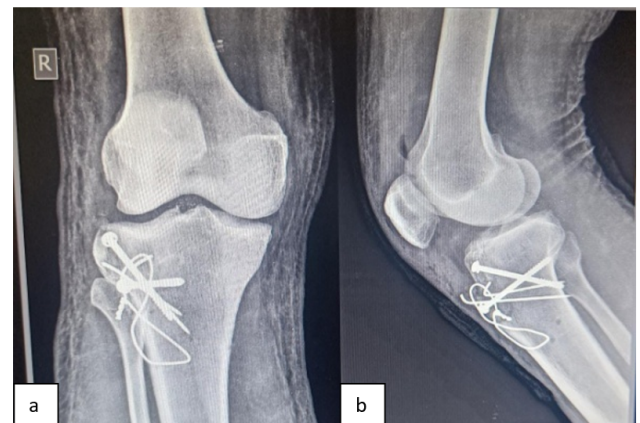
Showing follow-up radiographs of right knee. a): Anteroposterior; b): Lateral
